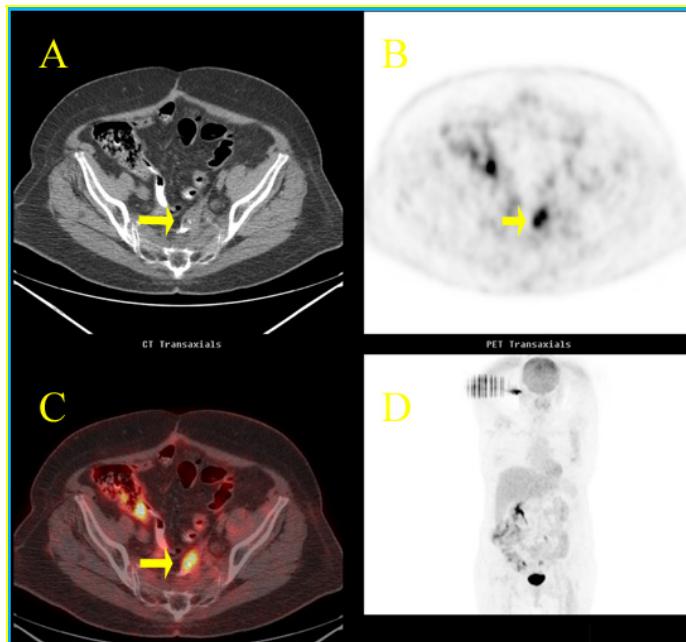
I. Axial section of CT (A). 64-year-old woman with adenocarcinoma, treated with surgery, chemotherapy and radiation therapy, with clinical suspicion of recurrence. Axial section of PET (B) and combined image (C). PET study in a coronal section (D). A small mass can be seen on the surgical site, showing an intense 18FDG uptake. The recurrence was confirmed with surgery.
